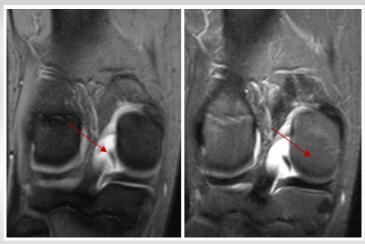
A meniscal fragment (arrow) has been displaced into the intercondylar notch and resembles the anterior cruciate ligament on a coronal magnetic resonance imaging.
